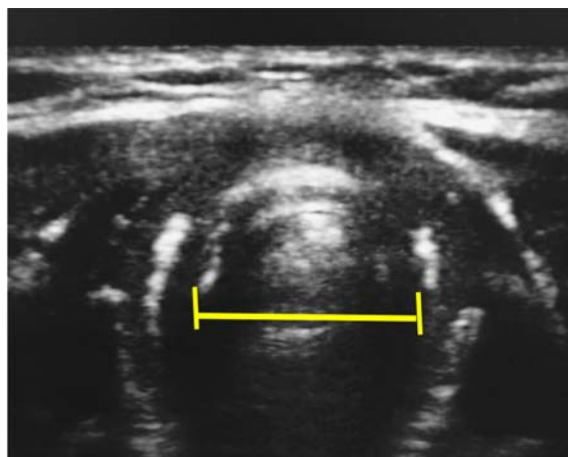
Ultrasound image of the transverse diameter of the subglottic area in the midline of the anterior neck with the patient in a supine position.
